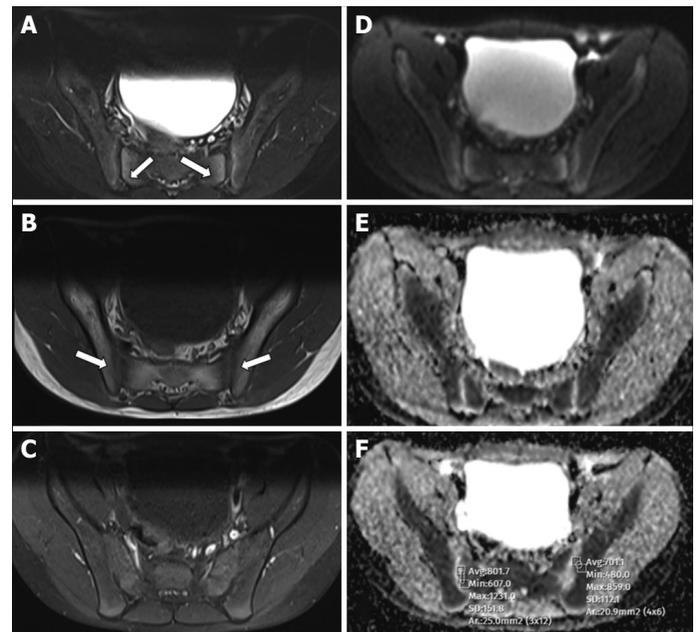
Images of the STIR (A), T1W (B), enhanced T1W (C), diffusion (D) and ADC (E, F) sequences taken in the axial plane of a 13-year-old male patient are viewed, respectively. Flaring is observed in the subchondral bone marrow adjacent to the SIJ, more prominently on the sacral faces in STIR images. These areas were hypointense in T1W series and no significant enhancement was detected. It is slightly hyperintense on DWI, and ADC values were found to be $0.62\text{--}0.87 \times 10^{-3}$ mm²/s in these areas in ADC mapping.
